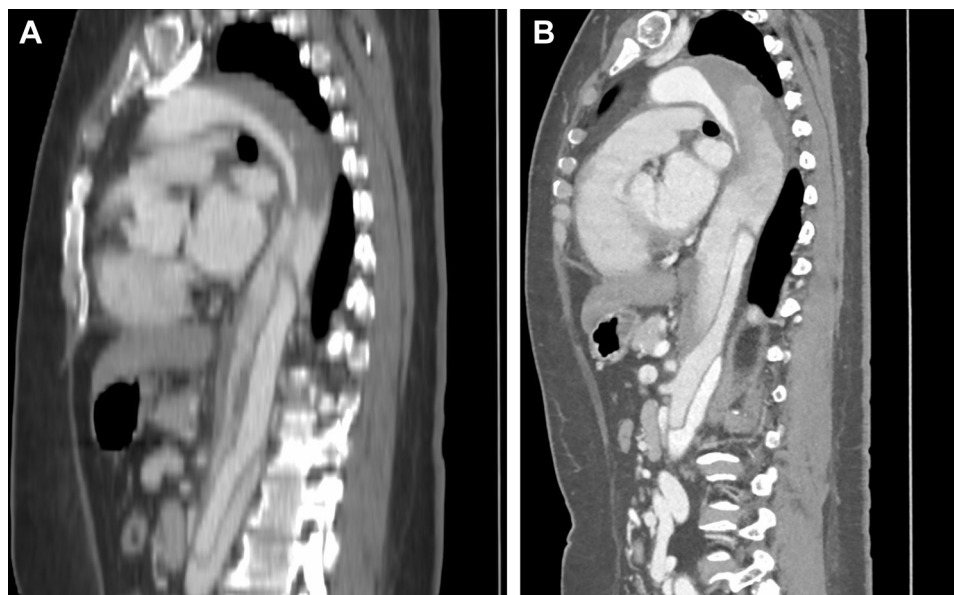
Enhanced preoperative computed tomography (CT) of type B acute aortic dissection. A, Enhanced CT scan at onset shows a patent false lumen with partial thrombosis from the descending aorta to the thoracoabdominal aorta. B, Recanalization of the thrombosed false lumen and dilation of the descending aorta 6 months after onset.
